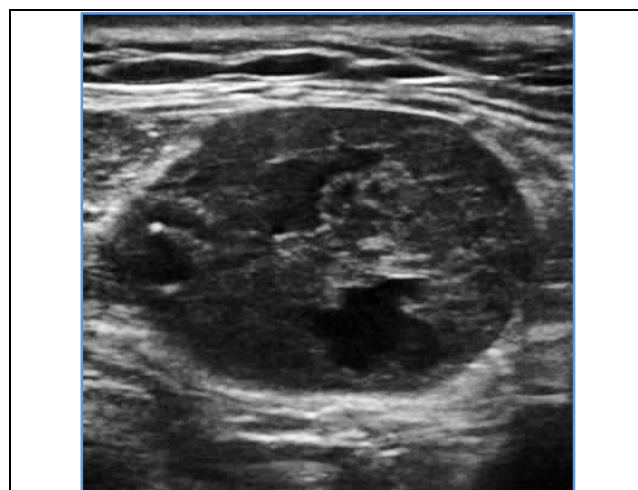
Warthin's Tumour: Ultrasonography of Left Parotid Gland Shows Well-Defined, Oval Shape, Hypoechoic Lesion with Irregular Cystic Areas Within It
